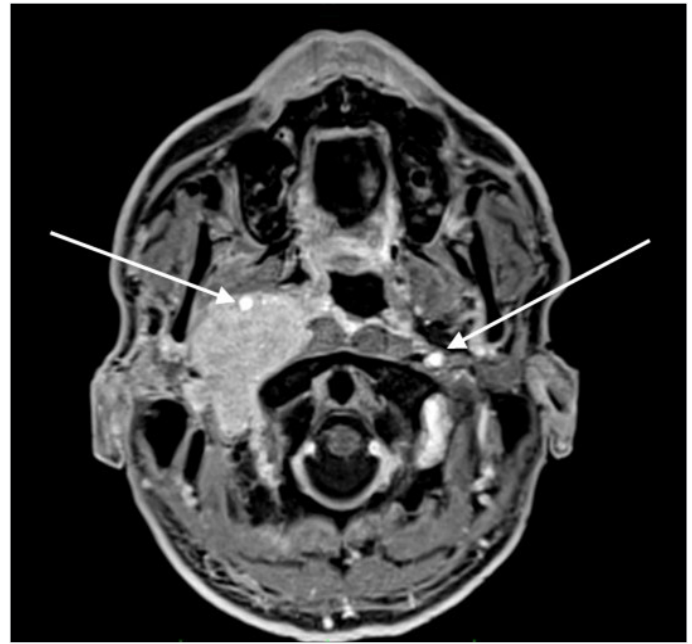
Contrast-enhanced MRI scan of a tumor of the neck and skull base on the right side in axial projection; the internal carotid artery is being displaced forward by the tumor.
